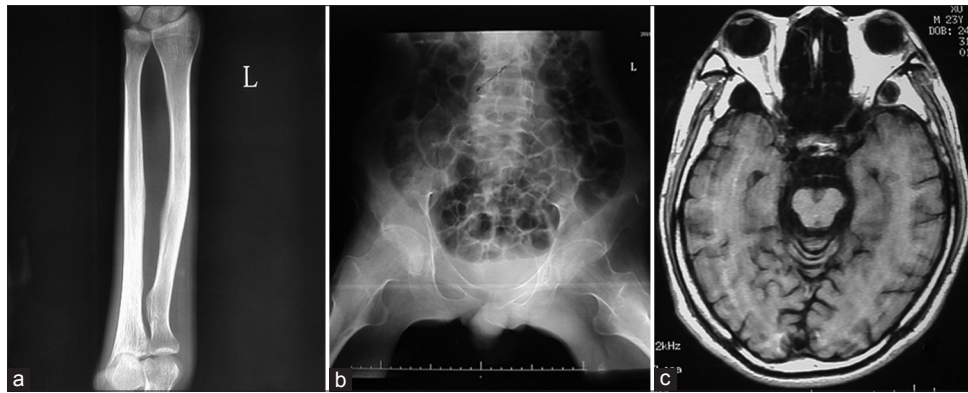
Bone X-ray and brain MRI of the proband. Bone X-ray of the proband shows no osteolysis, osteosclerosis or cortical thickening (a and b). Brain MRI presents cerebellum and brain stem atrophy (c). MRI: Magnetic resonance imaging.
